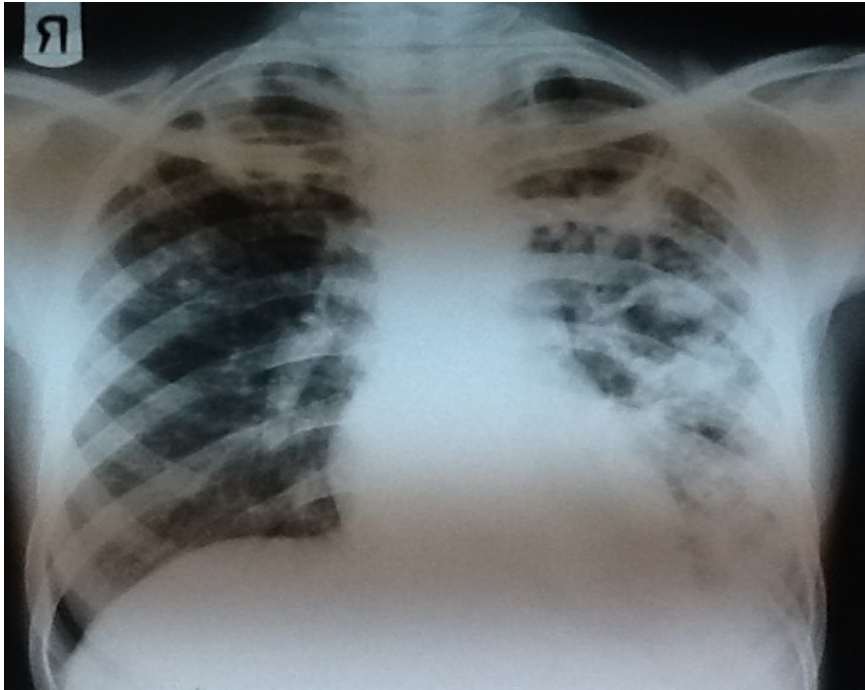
PA chest radiograph of 48 year old patient showing fibrocavitary lesion in entire left lung field and right upper zone (CD4 Count = 468cells/ μ l, VL = 200 copies/ml).
